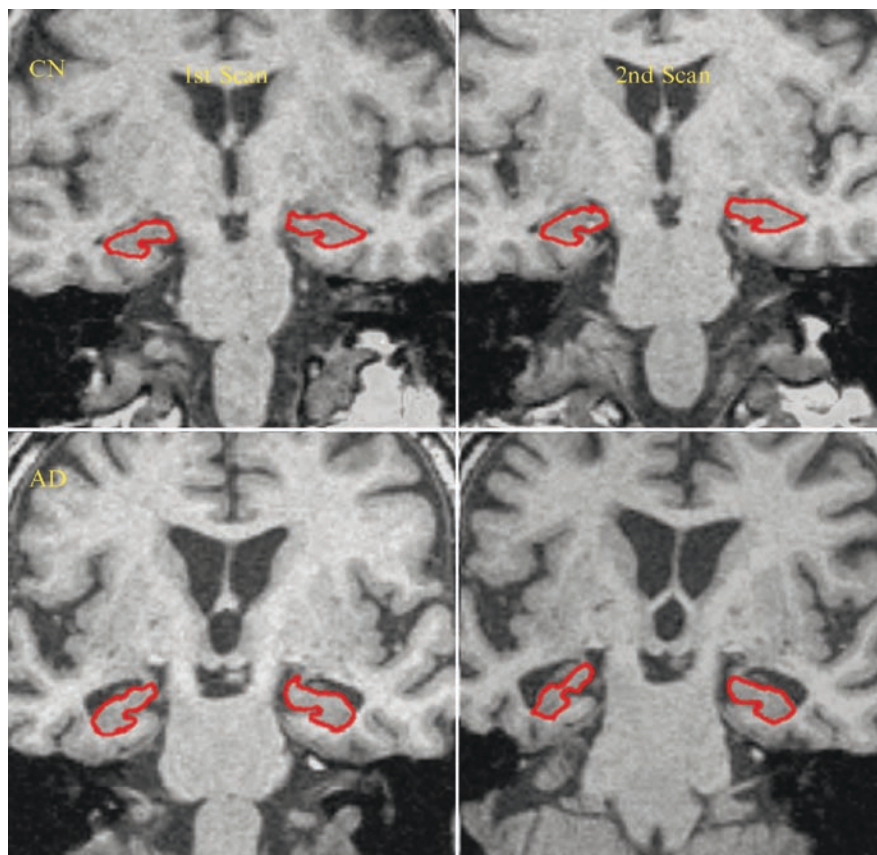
Hippocampal atrophy detected in AD patients. Two MRI scans 1 year apart in the same individuals are shown. Hippocampi are indicated by the red trace on coronal sections. Marked atrophy (reduction of hippocampus area) is observed in an AD patient compared to an age-matched control subject. The area of hippocampus can be quantified as a biomarker of disease progression. Figure courtesy of Dr. Michael W. Weiner, University of California, San Francisco, CA
